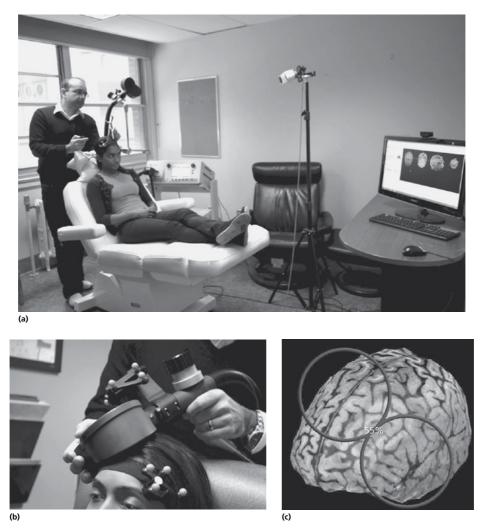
MRI-guided neuronavigation. (a) A neuronavigation suite uses a 3D position-capture camera, a pre-loaded MRI of the patient, and tracking markers on the coil and the patient's head to position the coil over the intended stimulation site during stimulation. (b) Tracking markers allow the camera to follow slight movements of the coil or the patient's head in real time, in order to maintain position over the target. (c) Neuronavigation software can establish the position of the coil vertex to an accuracy of <2 mm, and also create models of the geometry of the electrical field induced by the coil during stimulation.
